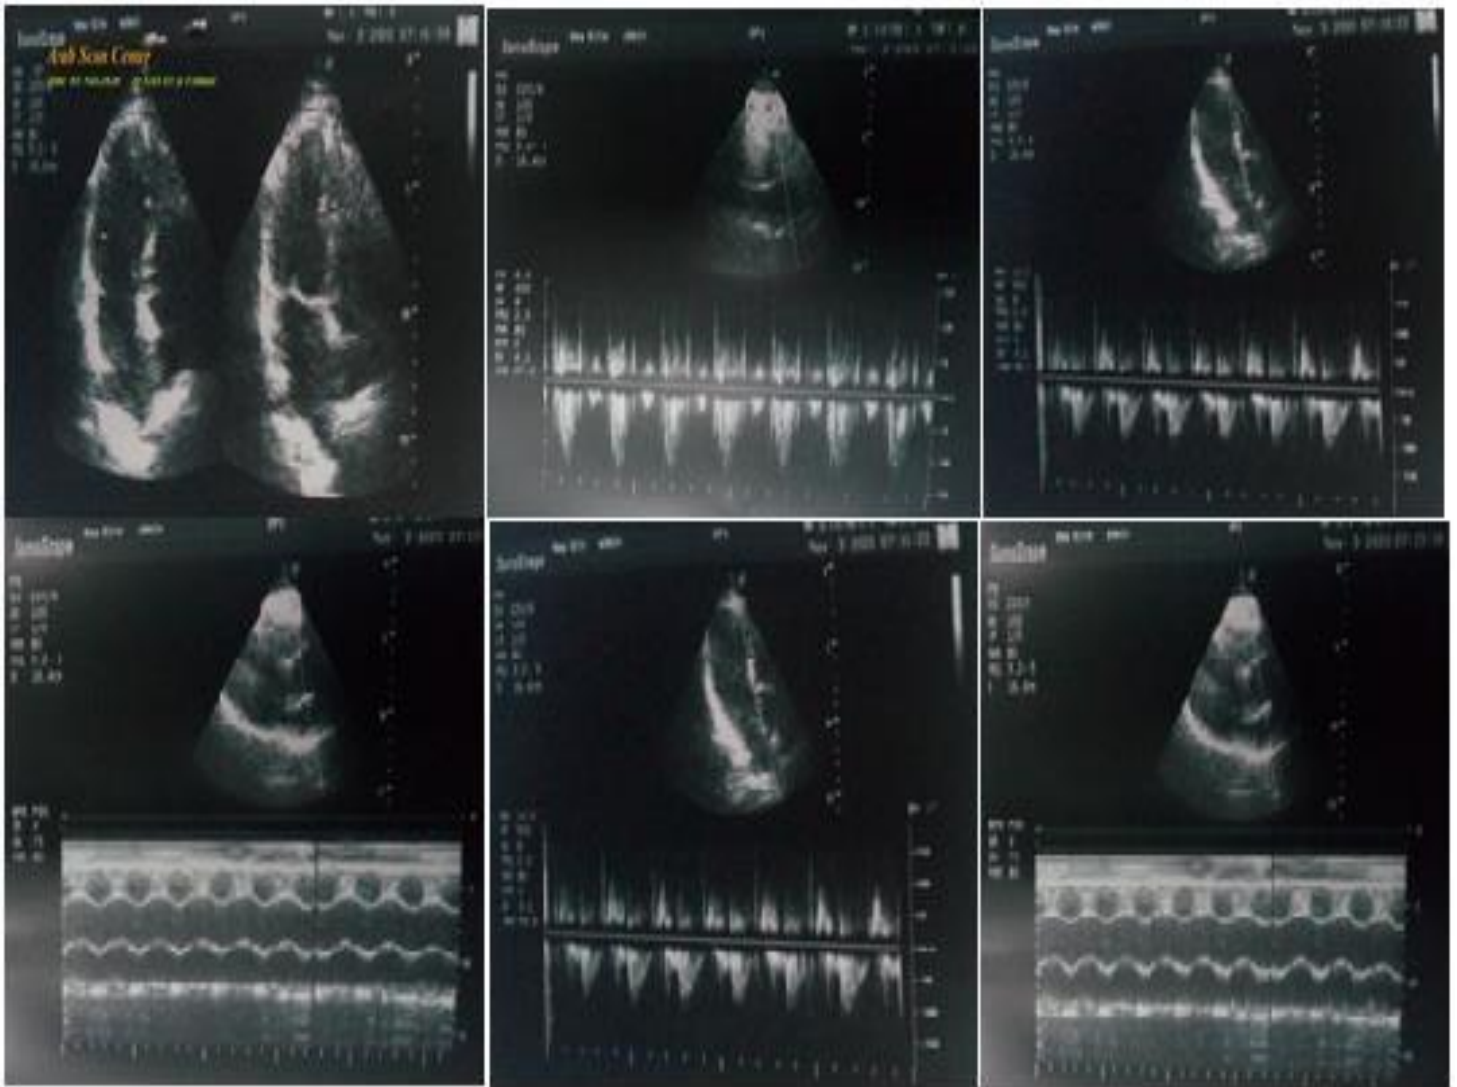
Echocardiography images were done on the second day of the presentation showing no abnormalities with EF of 67%.
